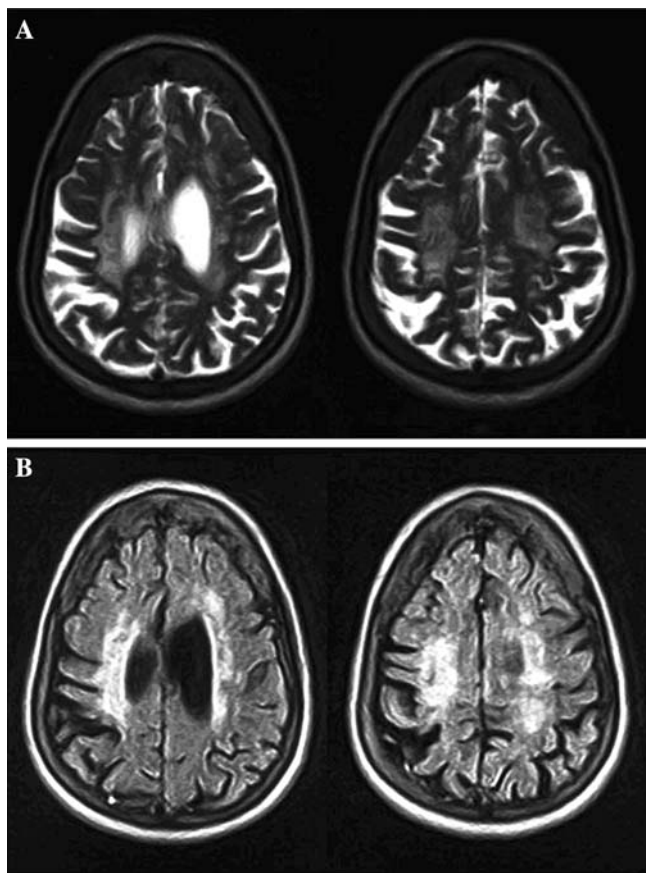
T2-weighted (a) and fluid-attenuated inversion recovery magnetic resonance imaging (b) of the proband (III-6) shows bilateral abnormal high intensity areas in deep cerebral white matter and bilateral cerebral atrophy. Atrophy is worse on the *right*
